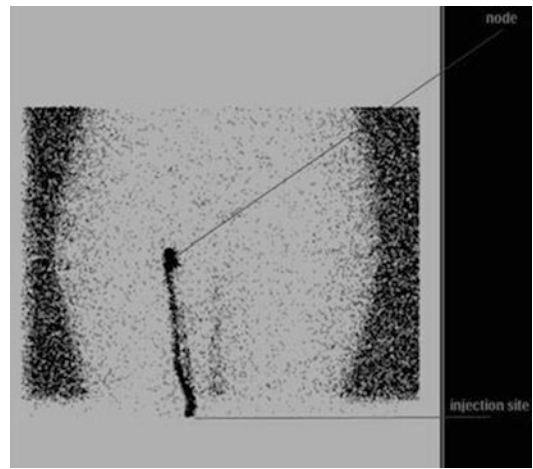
Lymphoscintigraphy: sentinel lymph node at the right inguinal area from a primary site at the right femur
